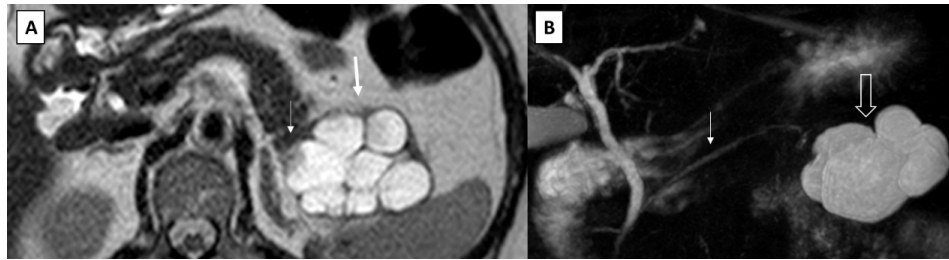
A: Axial T2-weighted magnetic resonance image showing a multiloculated macrocystic lesion (thick arrow), predominantly hyperintense on T2, with a solid component with intermediate T2 signal (thin arrow); B: Magnetic resonance cholangiopancreatography showing a normal caliber of main pancreatic duct (thin arrow), with no evidence of communication with the cystic lesion (empty arrow).
